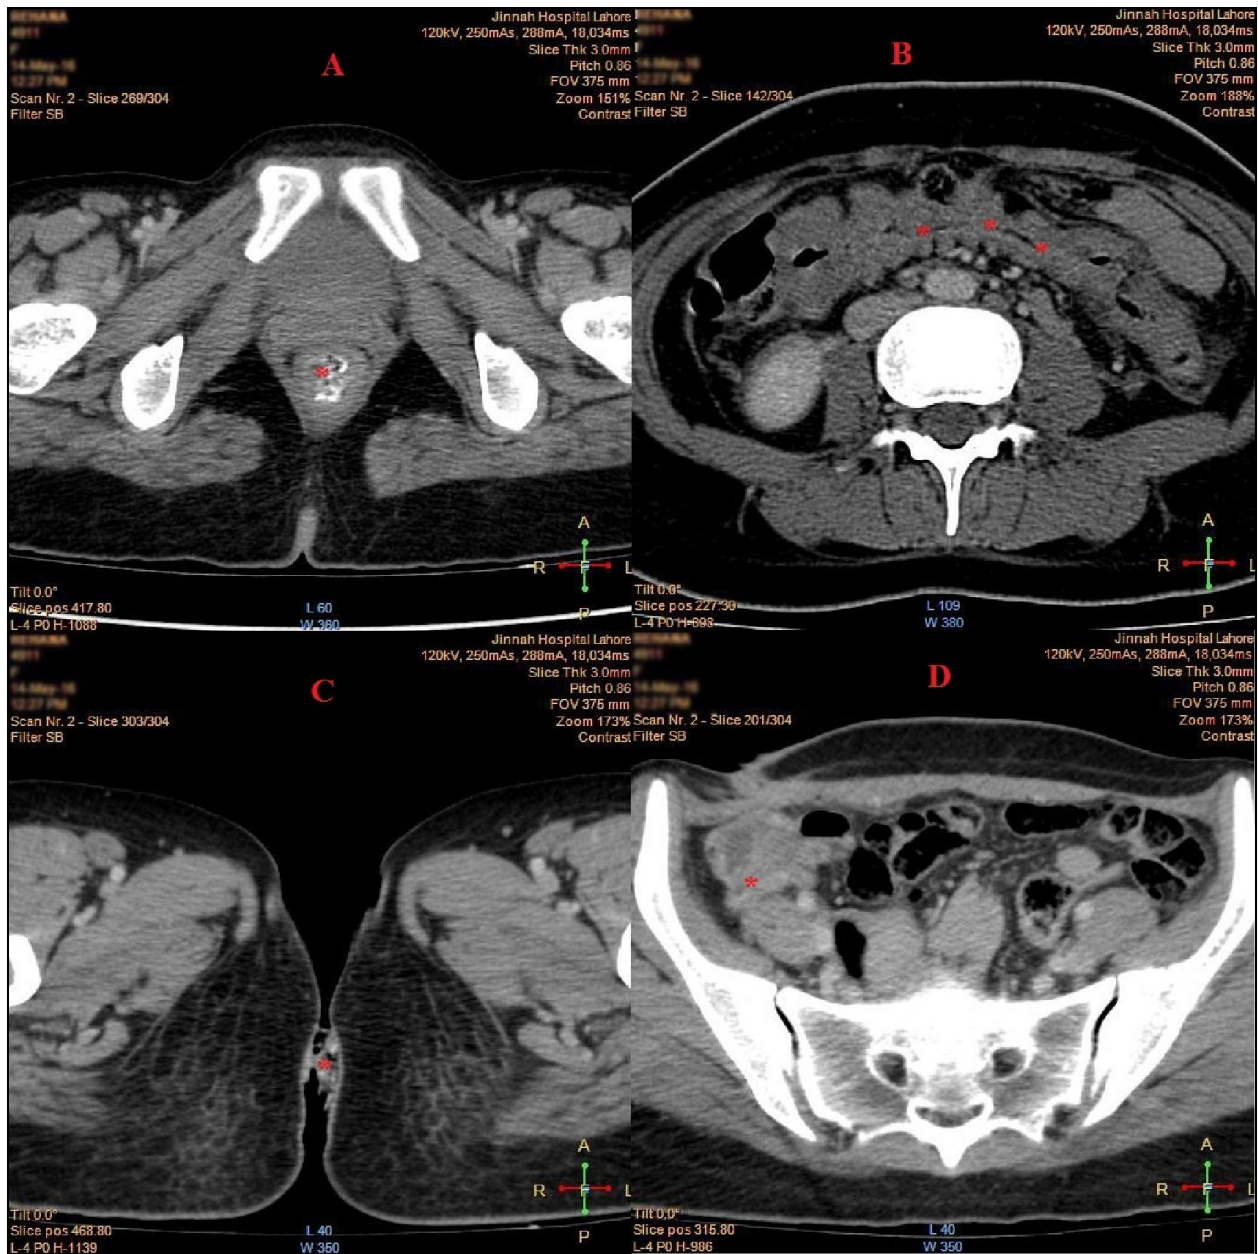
Axial post contrast CT scan slices showing A: Heterogenous density mass in rectum, B: Linear low density in transverse colon, C: Sponge protruding out through anal canal, D) Oedematous caecum
